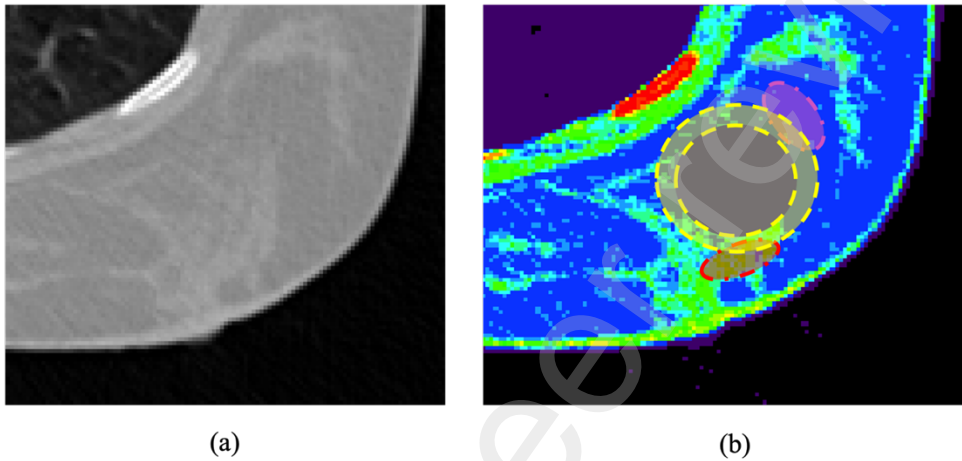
Original CT (a) and the segmented CT (b) from the conversion from HU to tissue, according to the reference tissue model of section 2.3. Looking inside the segmented breast in (b), adipose tissue appears in blue and glandular in green. The applicator is shown in grey, together with the three ROIs analyzed in the study: Adipose (pink), glandular (red) and average (yellow).
